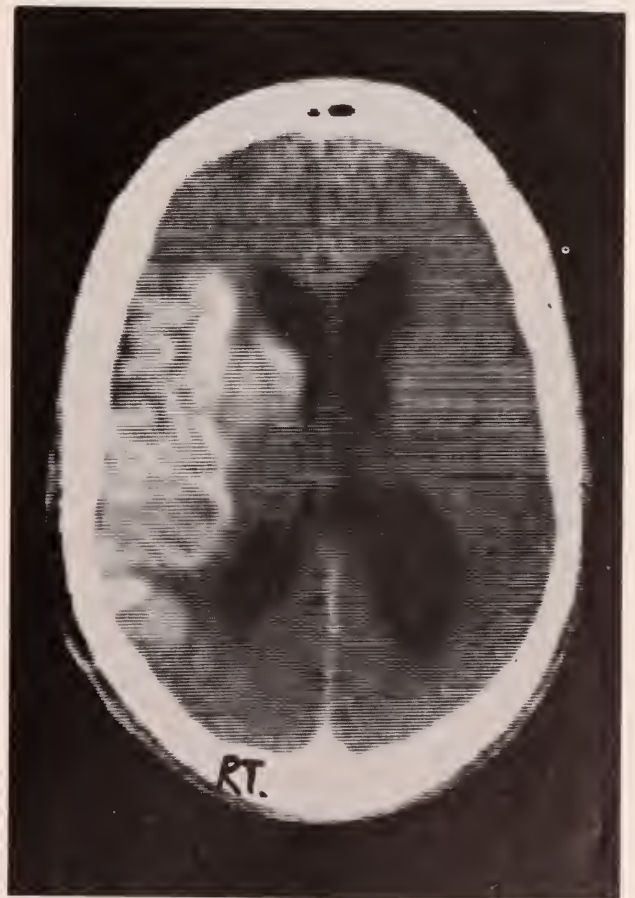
Case 2, post contrast CT scan.
